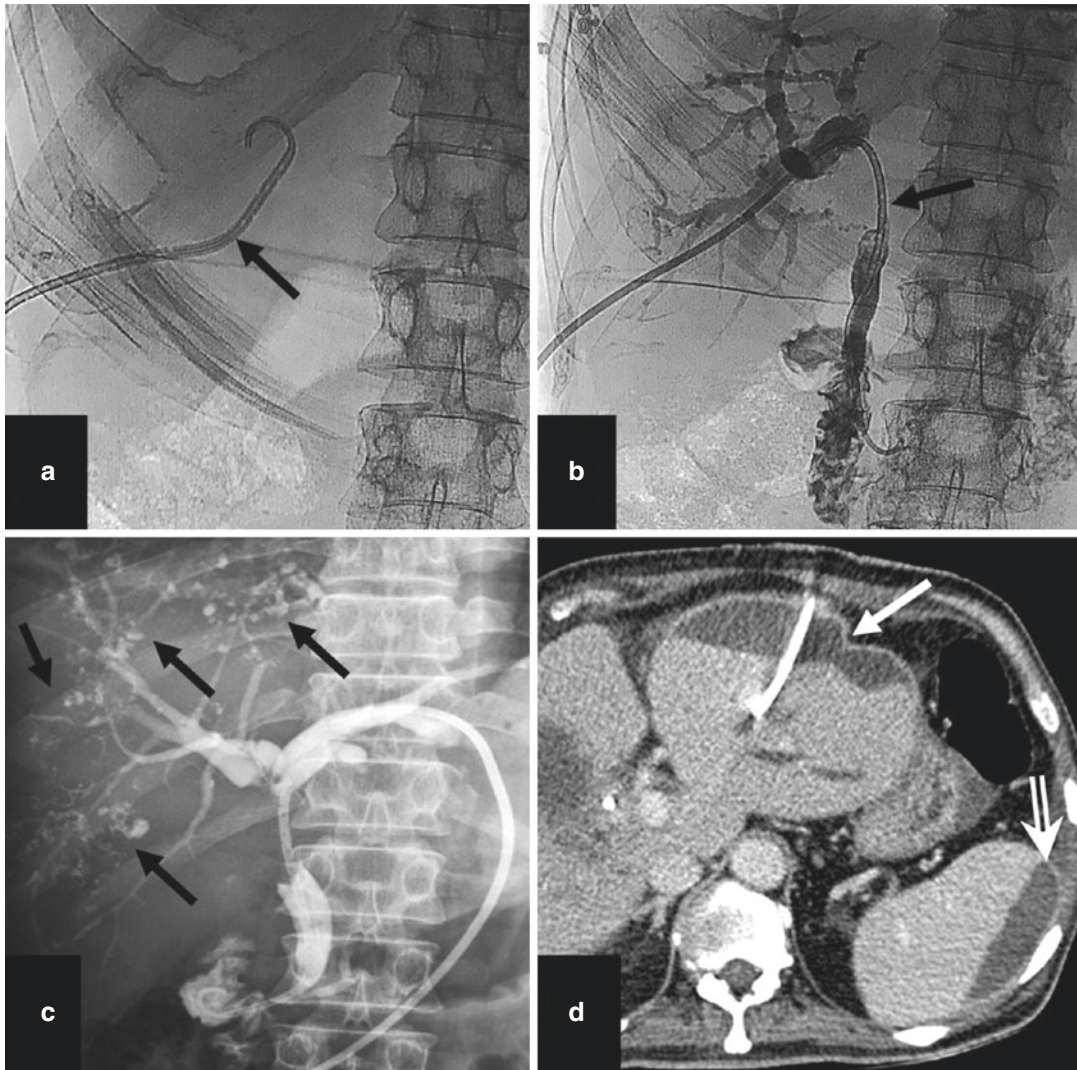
Other complications of PTBD. (a, b) Displacement of ring biliary catheter. (a) Radiograph shows displaced ring biliary catheter (arrow). (b) Repositioning of the catheter to its appropriate position (arrow). (c) Cholangitis. Cholangiogram shows multiple
